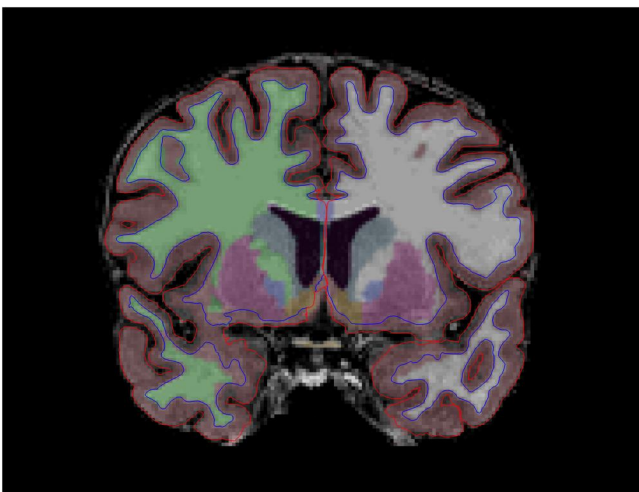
A coronal section of the T1-weighted sequence for a representative participant showing the labeling of subcortical regions of interest (mapped with different colors) following the FreeSurfer segmentation as well as the boundaries for the gray (red outline) and white matter (blue outline)
